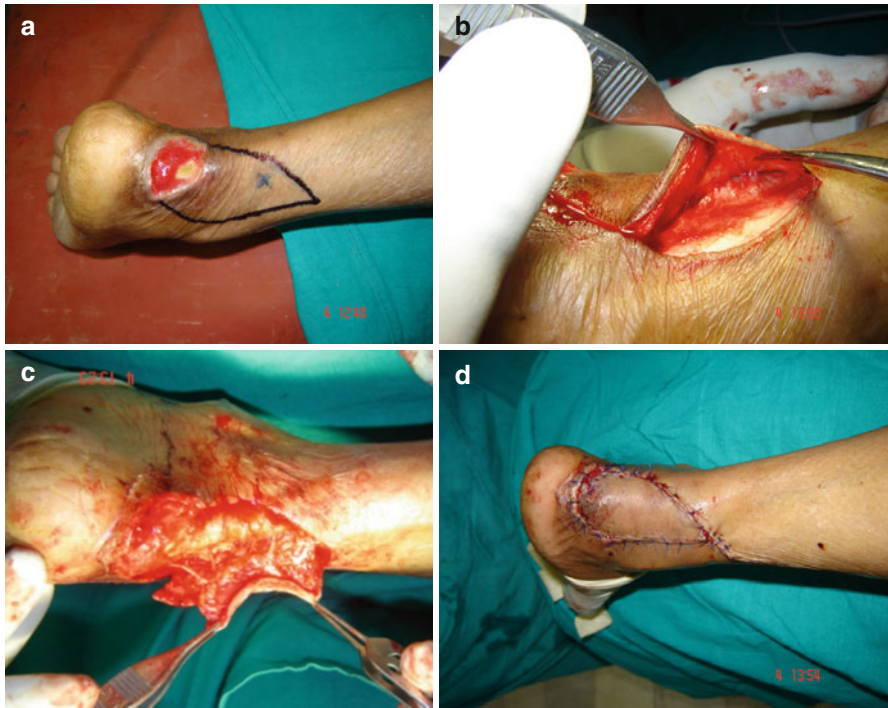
(a–d) Perforator-based V-Y advancement flap for posterior heel ulcer. The tentative flap marked and perforator was identified by Doppler and marked with X (a). The flap was elevated from lateral side and perforator was identified and preserved (b). Now the whole flap was elevated and the flap mobility was checked (c). The V-Y closure was done (d)
